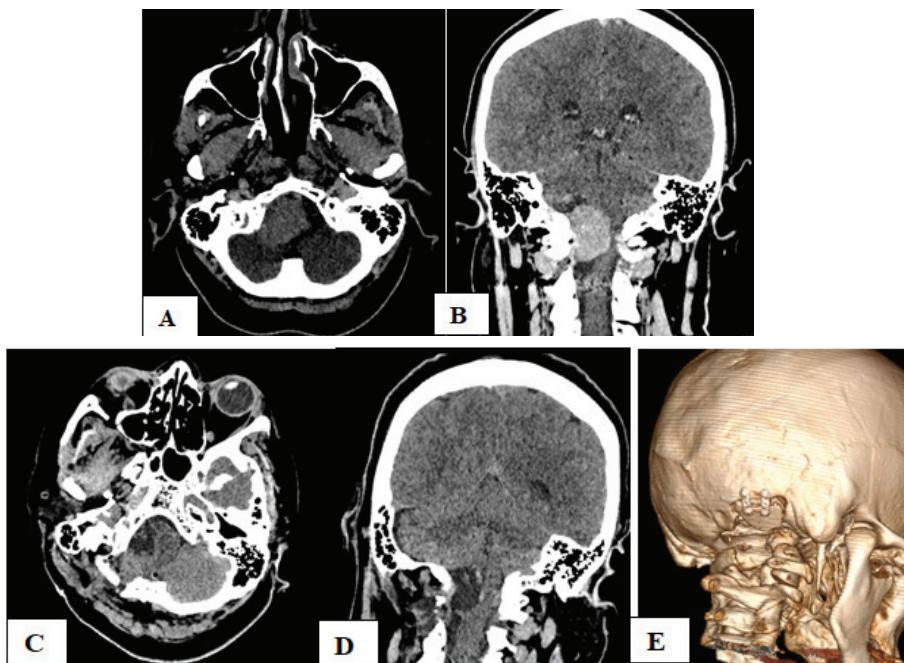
Foramen magnum meningioma ventro-lateral localization (CT preop - Fig. 5 A, B). The far lateral approach in combination with transcondylar approach and suboccipital retrosigmoid approach. Intraoperative neuromonitoring CN XII. Intraoperative neuromonitoring of pyramidal tracts. Total tumor removal, Simpson II (CT oafte op - Fig. 5 C, D,E)
